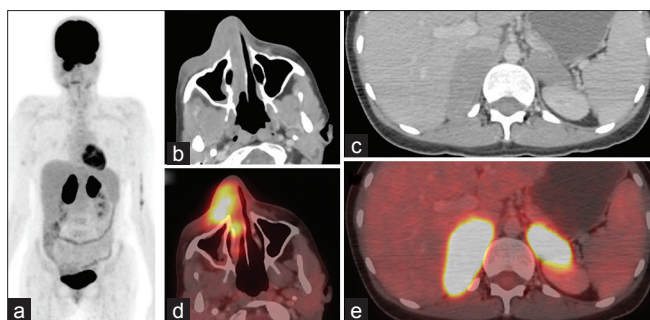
18 Fluoride-fluoro-deoxy glucose positron emission tomography-computed tomography (18F-FDG PET-CT) performed showed intense FDG uptake in heterogeneously enhancing soft tissue in the right nasal cavity with extension into the skin of the cheek and right lower eye lid (a - maximum-intensity projection, b - axial CT, c - fused PET-CT). Intense FDG uptake was also noted in enhancing soft tissue bilateral adrenal masses (d - axial CT; e - fused PET-CT) indicating disease involvement
